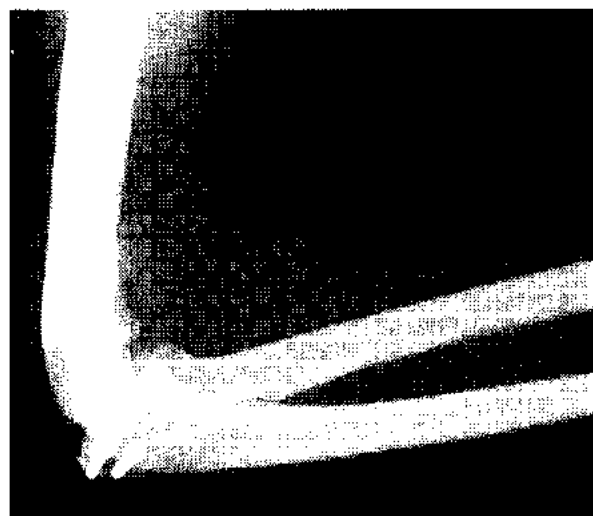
Lateral radiograph showing an intraarticular two-column fracture of the distal humerus, treated with screw fixation. Note the screw fixation of the olecranon fracture.
